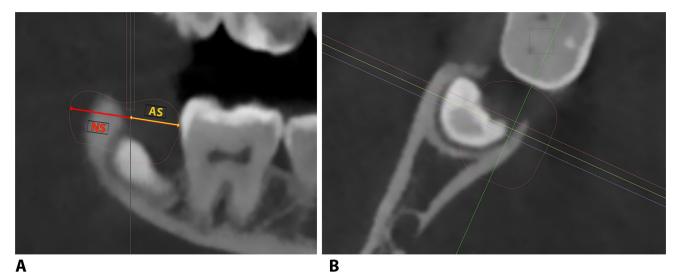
Cone beam computed tomography (CBCT) images showing the measures on the virtually aligned crown: (A) Red line representing the necessary space and yellow line representing the available space in the frontal view. (B) Bucco-lingual position of the virtually aligned crown in the axial view.
